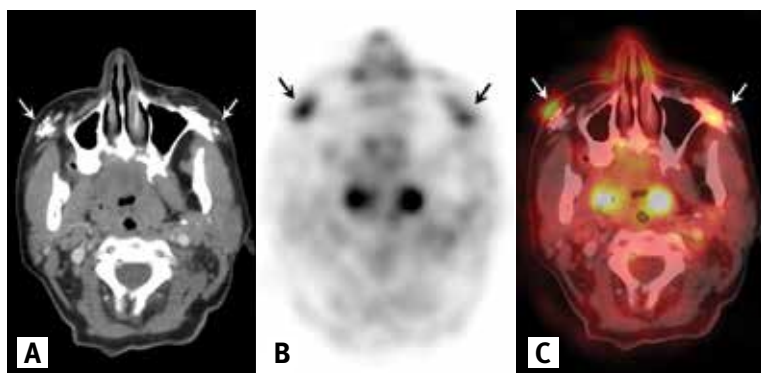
[A] Corresponding axial slices showing microcalcifications on computed tomography (CT), [B] increased fludeoxyglucose ^{18}F -FDG uptake on positron-emission tomography (PET), and [C] superimposition of both findings on fusion in patient #5
